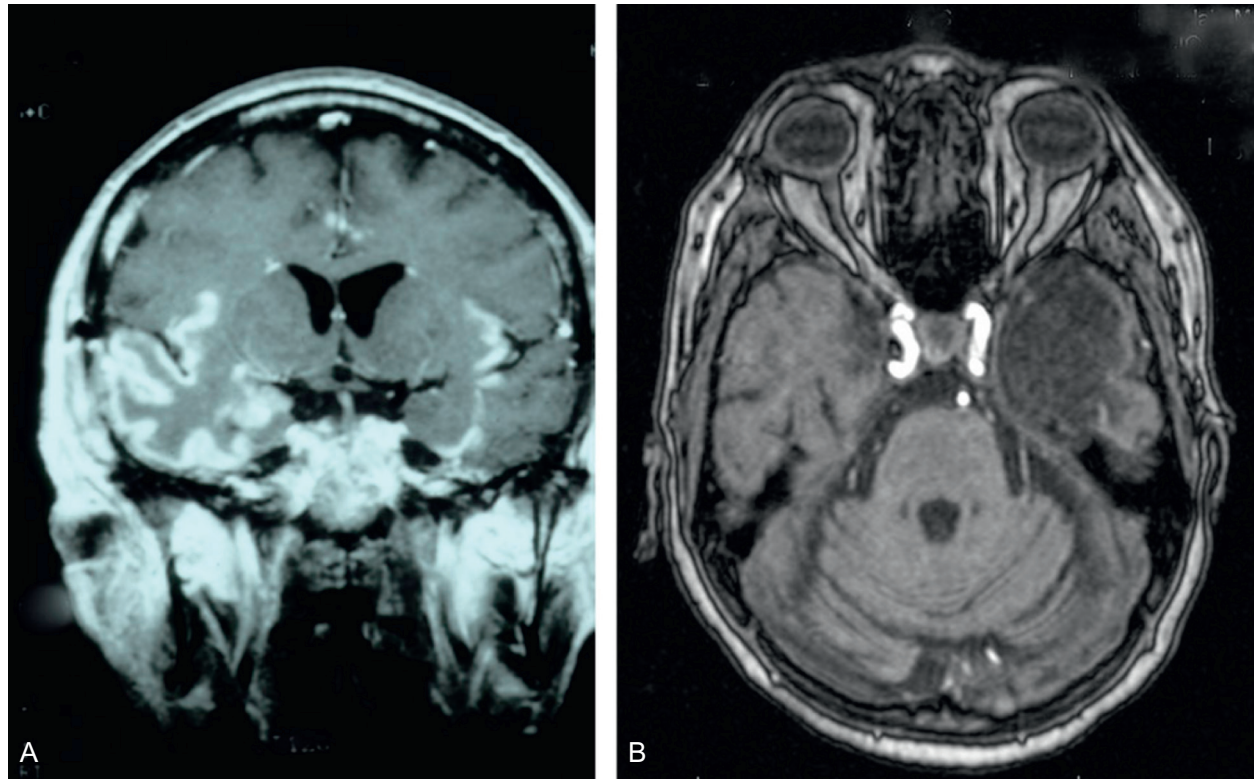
■ A, Magnetic resonance imaging (MRI) of herpes simplex virus encephalitis. T2-weighted fluid-attenuated inversion recovery (FLAIR) sequence showing increased signal in right temporal lobe, insula, and orbitofrontal cortex. There is also involvement of the left insula. B, T1-weighted MRI 6 months after infection, showing massive destruction of the left temporal lobe.
